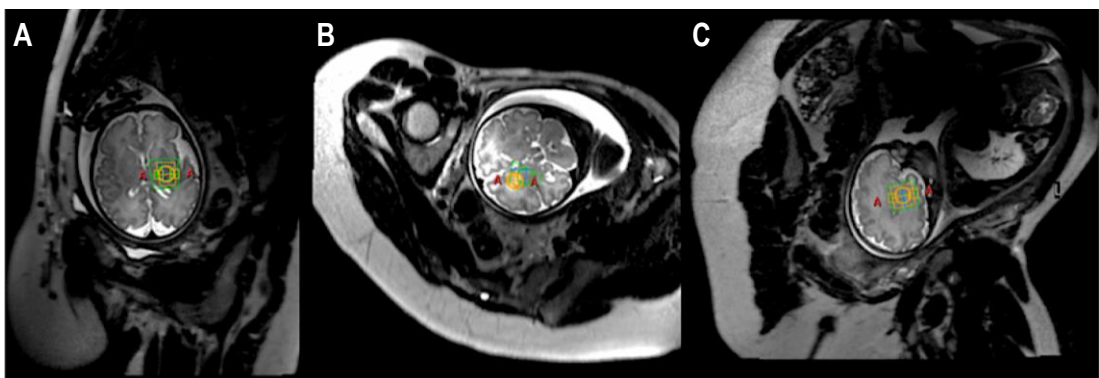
A T2-weighted dynamic single shot fast spin echo sequence (T2ssFSE)
